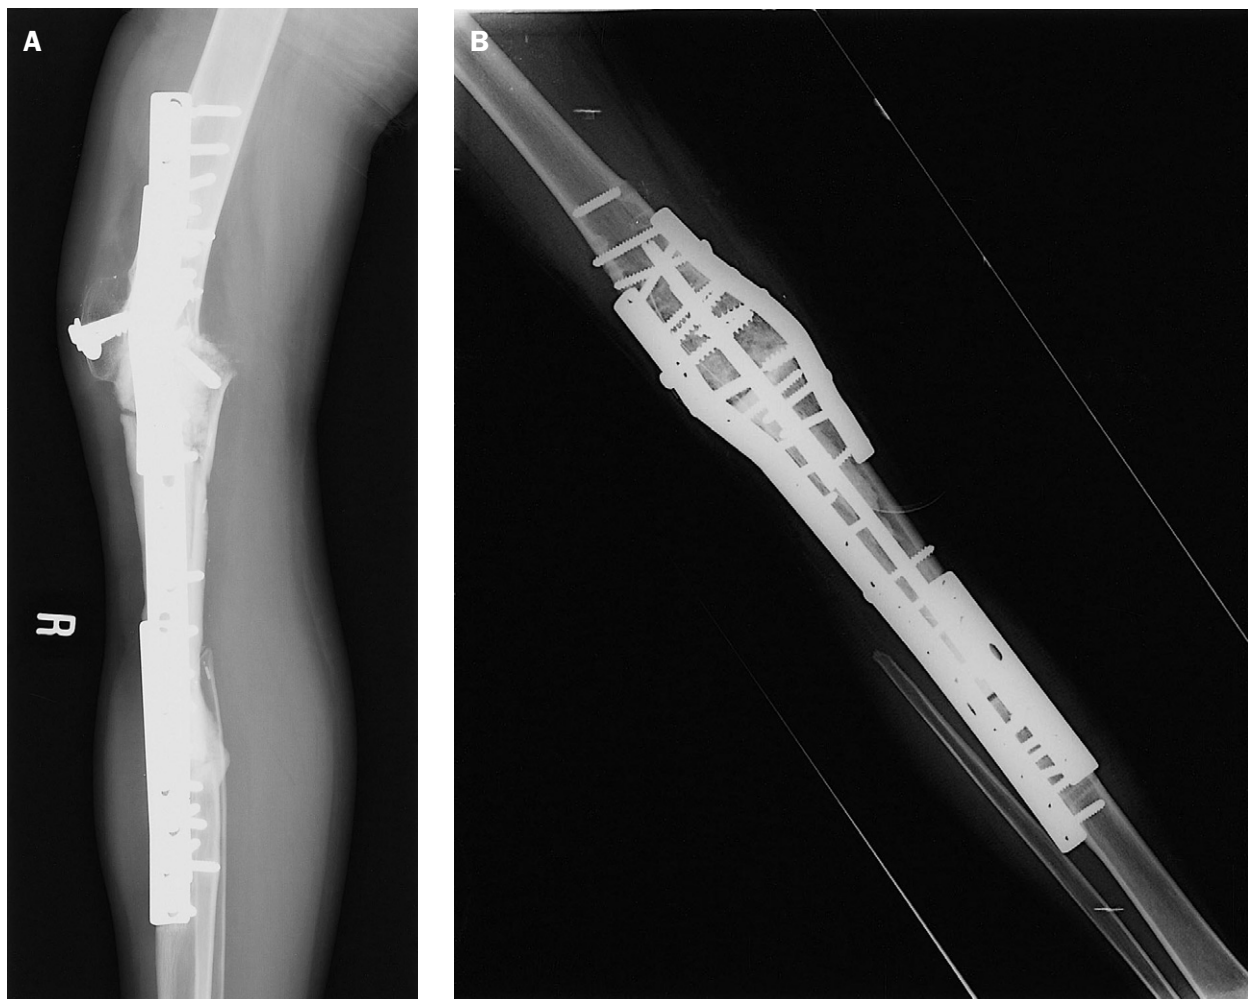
An 18-year-old girl with proximal tibia osteosarcoma of the right leg: (A) an allograft fracture was noted on X-ray 3 years postoperatively; (B) an immediate postoperative X-ray shows revision with a new allograft augmented with bone cement.
